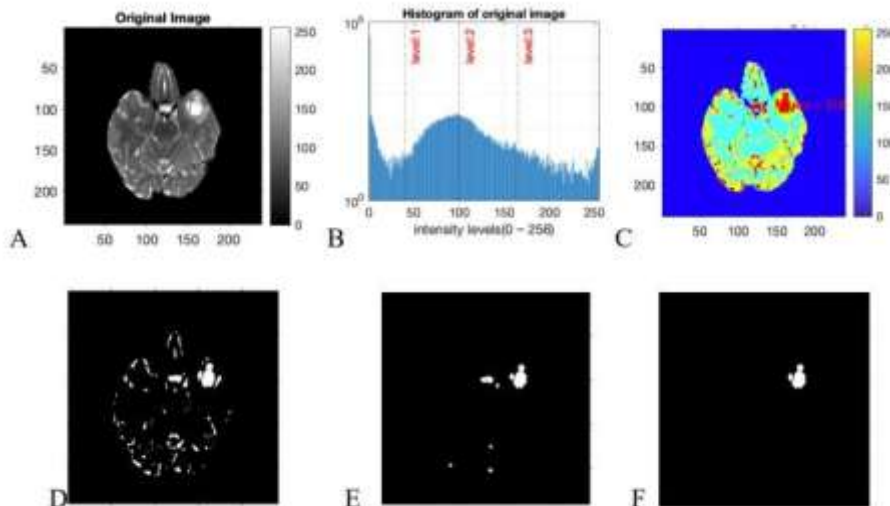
(A) Original MRI scan; (B) corresponding histogram with selected threshold levels; (C) color-segmented image; (D) red-colored tumor core from (C); (E) outcome of morphological processing; (F) final result after connected component analysis.
